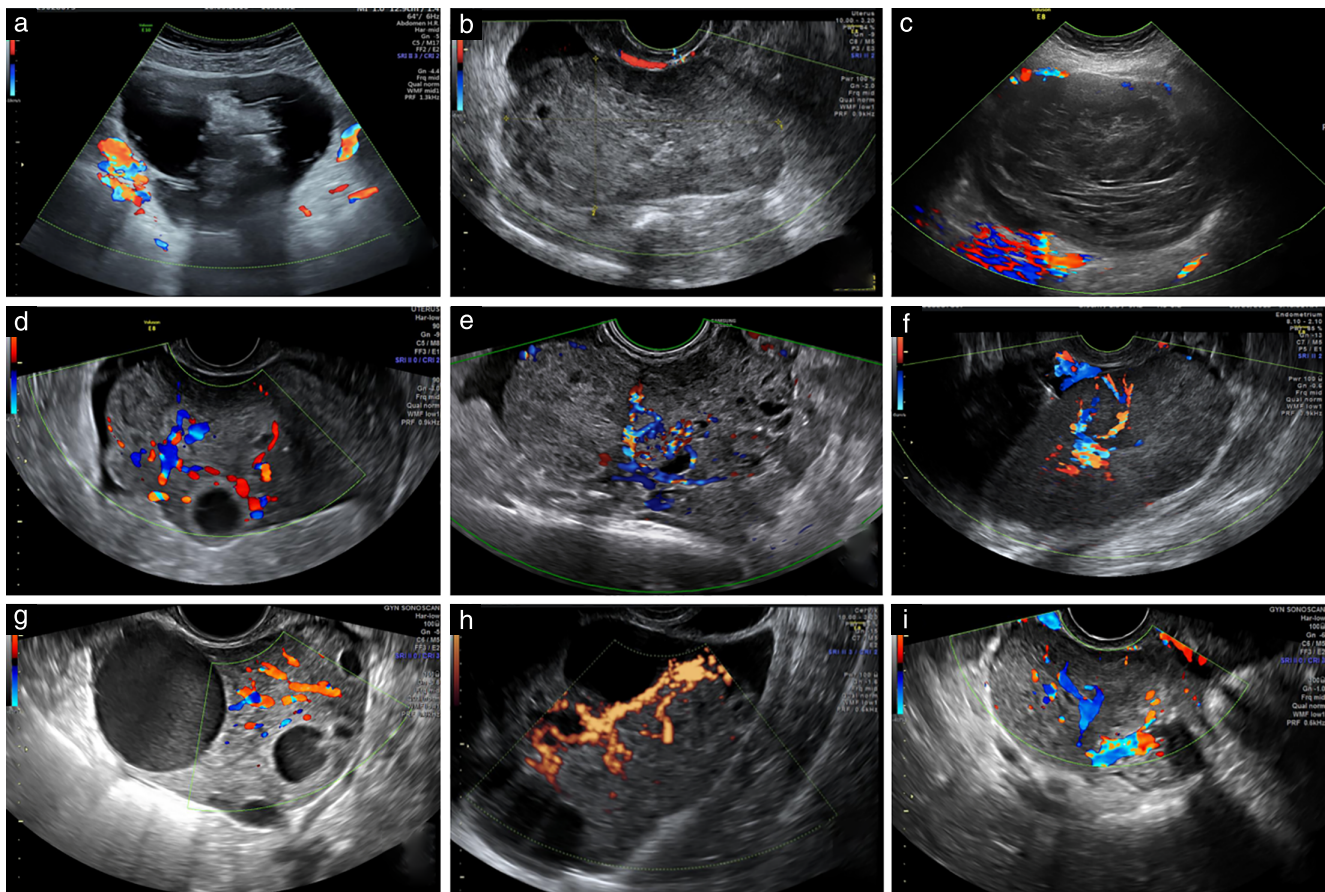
Color Doppler images of twisted adnexa without (a–c) and with (d–i) vascularization.
